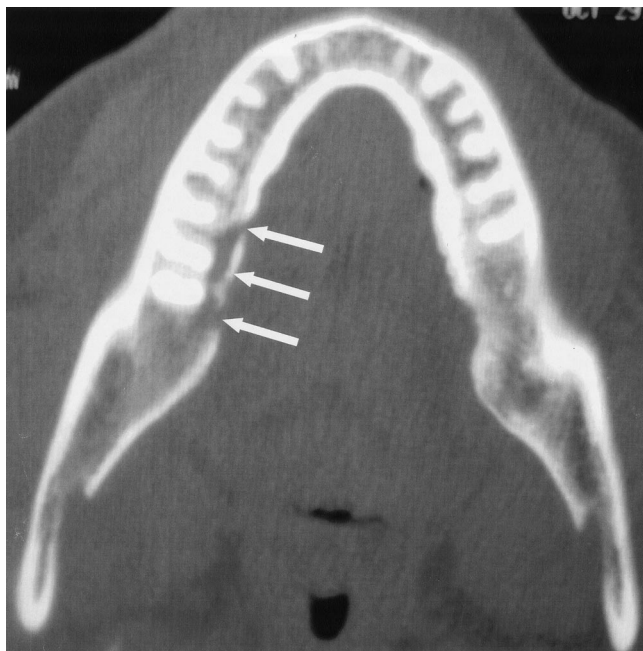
Axial view of a computed tomographic scan with contrast showing a linear lucency along the medial aspect of the body of the right mandible with associated defect in the lingual cortex and the level of the first and second molars.
